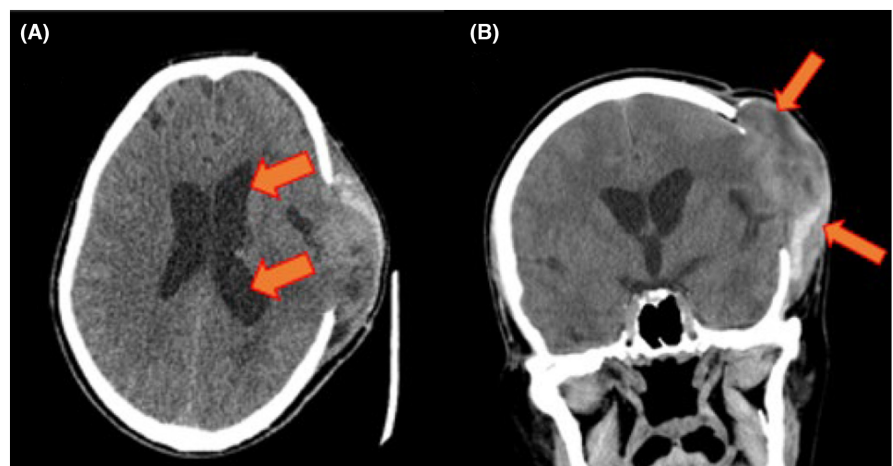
Computed tomography (CT) brain axial (A) and coronal views (B) showing hydrocephalus and herniation of the brain through the craniectomy defect.
